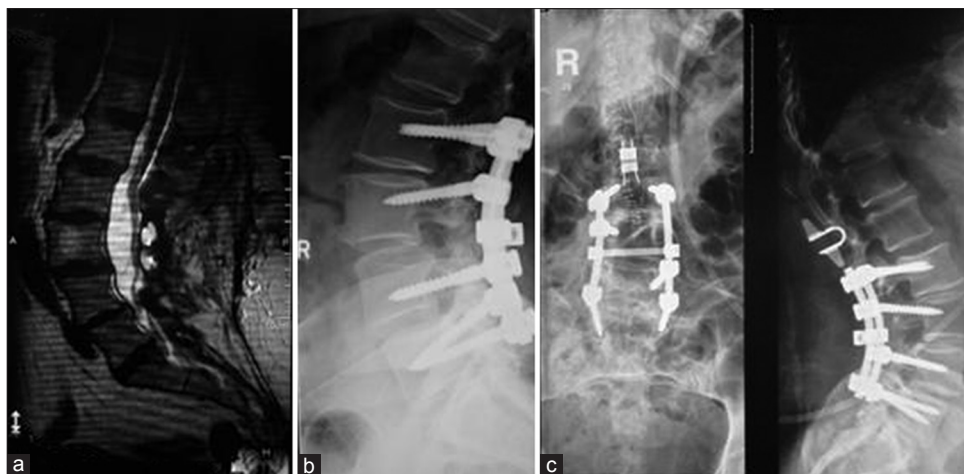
(a) Pre-operative T2 Sagittal lumbosacral spine magnetic resonance imaging for adjacent segment disease. (b) Pre-operative lumbosacral spine X-ray for adjacent segment disease. (c) Post-operative lumbosacral spine X-ray with interspinous distracter showing increase in adjacent segment disc height
